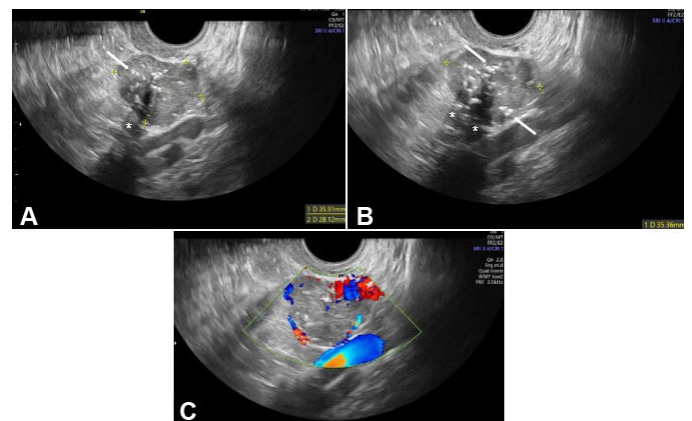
(A and B) Transvaginal ultrasound showing a solid, well-defined lobulated mass ($36 \times 28 \times 35$ mm) with mixed echogenic pattern, scattered hyperechoic foci (white arrows) and acoustic shadowing (*), adjacent to the left ovary. (C) Color Doppler shows moderate peripheral vascularization (color score 3/4).
